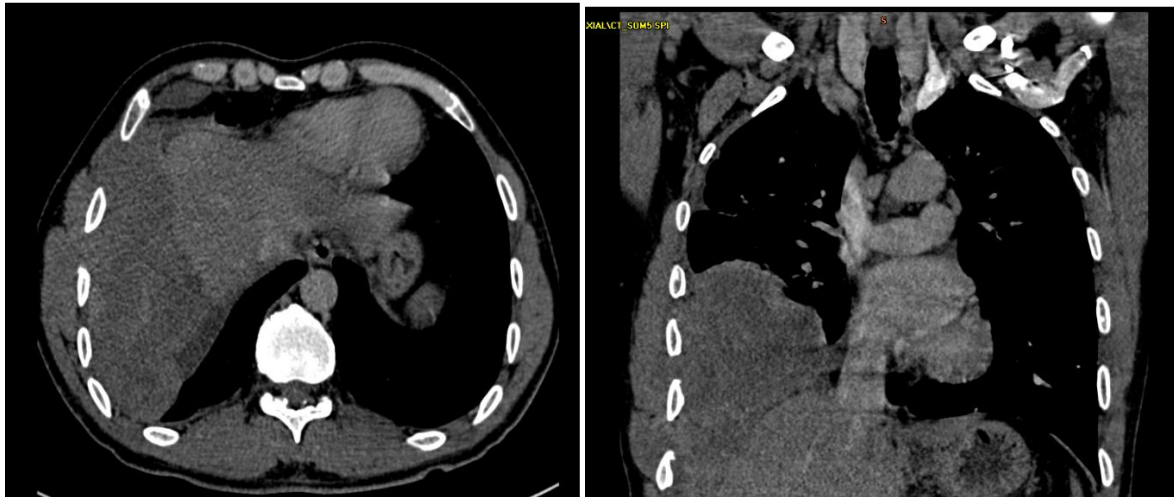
CT scan (axial and coronal sections) Locally infiltrating right pleural lesion associated with homolateral pleural effusion
